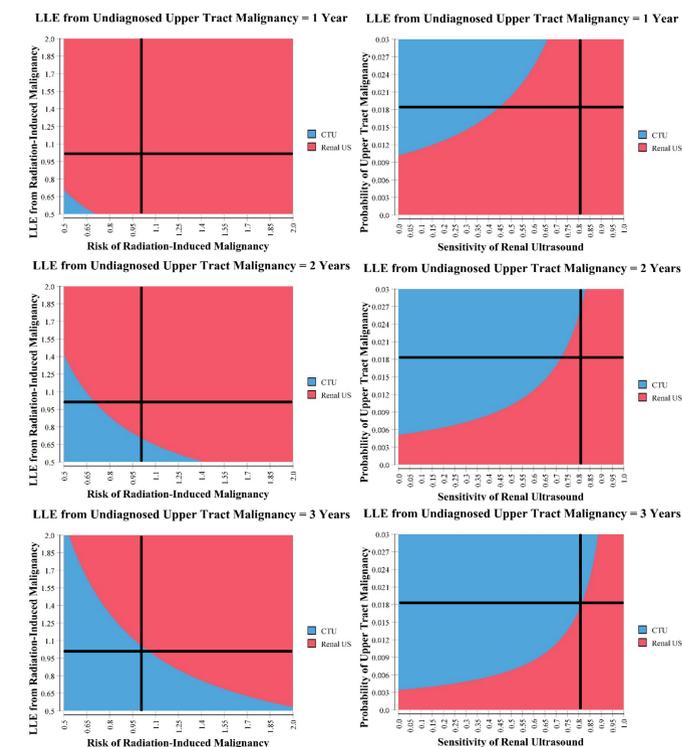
2-way sensitivity analyses performed as LLE from undiagnosed upper tract malignancy is varied from 1 to 3 years. Regions in red represent the frontier of inputs at which RUS is superior to CTU, while blue represents the range of inputs at which CTU is superior to RUS. Black lines represents model inputs as depicted in Table 1. Abbreviations: LLE, loss of life expectancy; CTU, CT Urogram; RUS, Renal Ultrasound.
